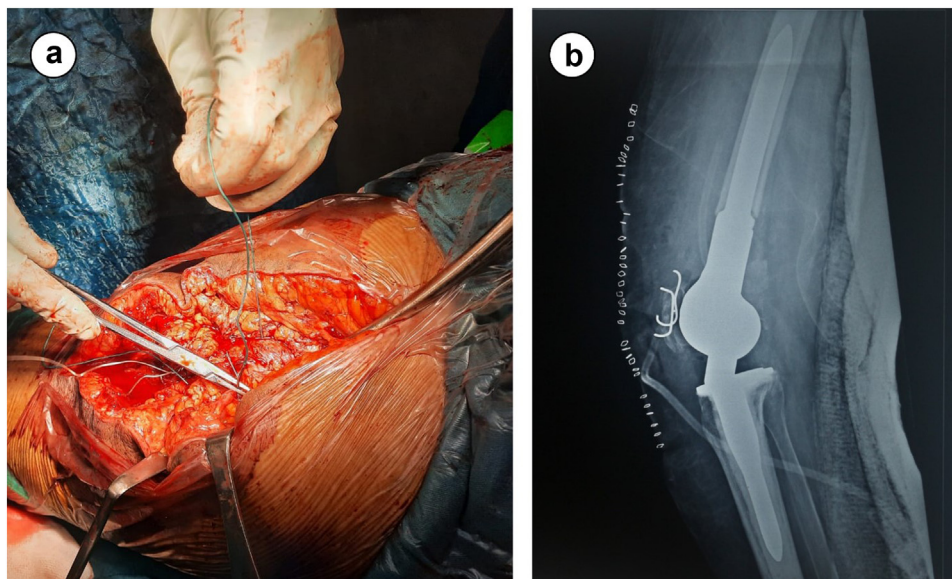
(a) Intraoperative picture showing the transosseous sutures used, in addition to the fixation with k wires. (b) Postoperative radiograph.
